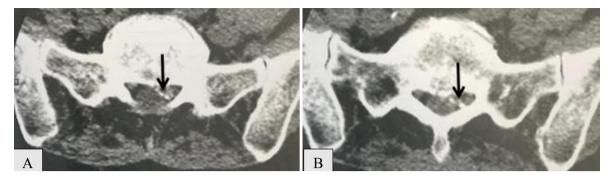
(A-B) Lumbosacral CT after three epidural steroid infiltrations: calcific epiduritis (arrows).
